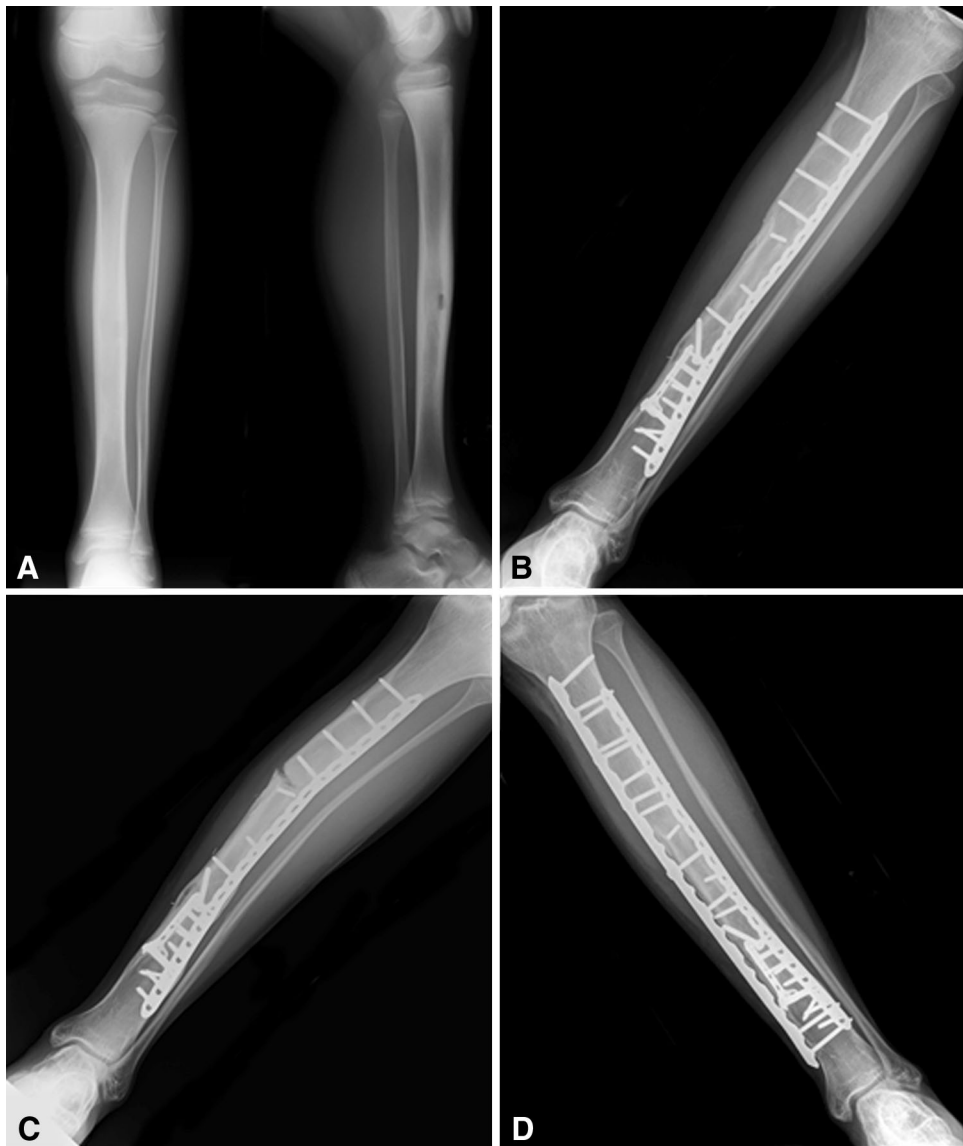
Preoperative radiographs (A) show a patient with a tibial Ewing’s sarcoma. The patient underwent the Capanna technique for limb salvage surgery and at 20 months postoperatively union was
